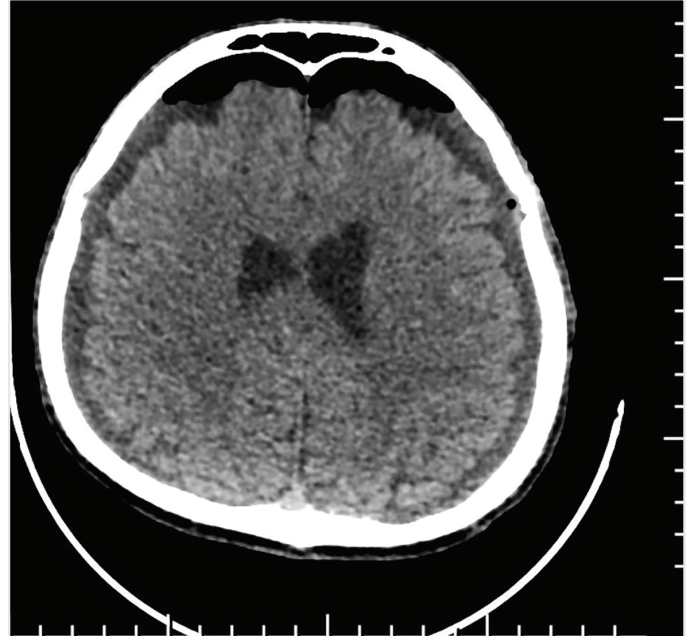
During the second surgery, air aspiration was performed, and the subdural space was filled with physiological saline solution. Postoperative axial computed tomography imaging in the parenchymal window revealed reduced pneumocephalus in both subdural spaces. Air densities secondary to the operation are in both frontal regions
